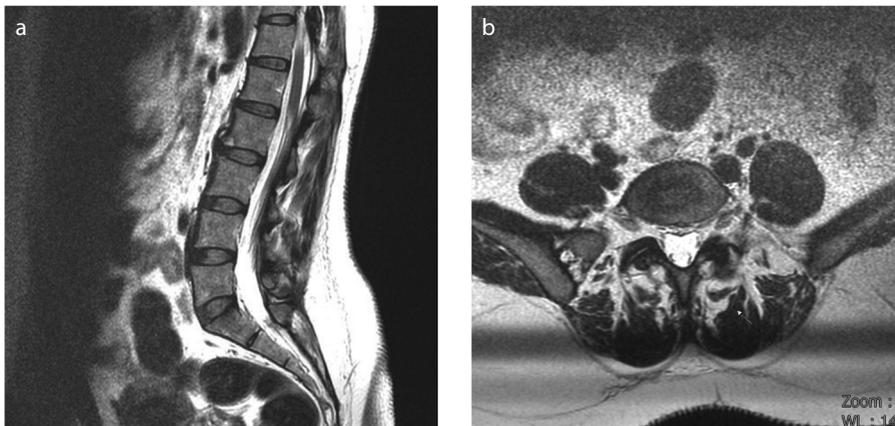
a, b. A 40-year-old female patient with grade 1 LMM atrophy without disc hernia. Midsagittal image (a) shows normal L4-L5 and L5-S1 discs; no significant loss of height or disc hernia is seen. Axial T2-weighted image (b) shows grade 1 LMM atrophy at L5-S1 level.
